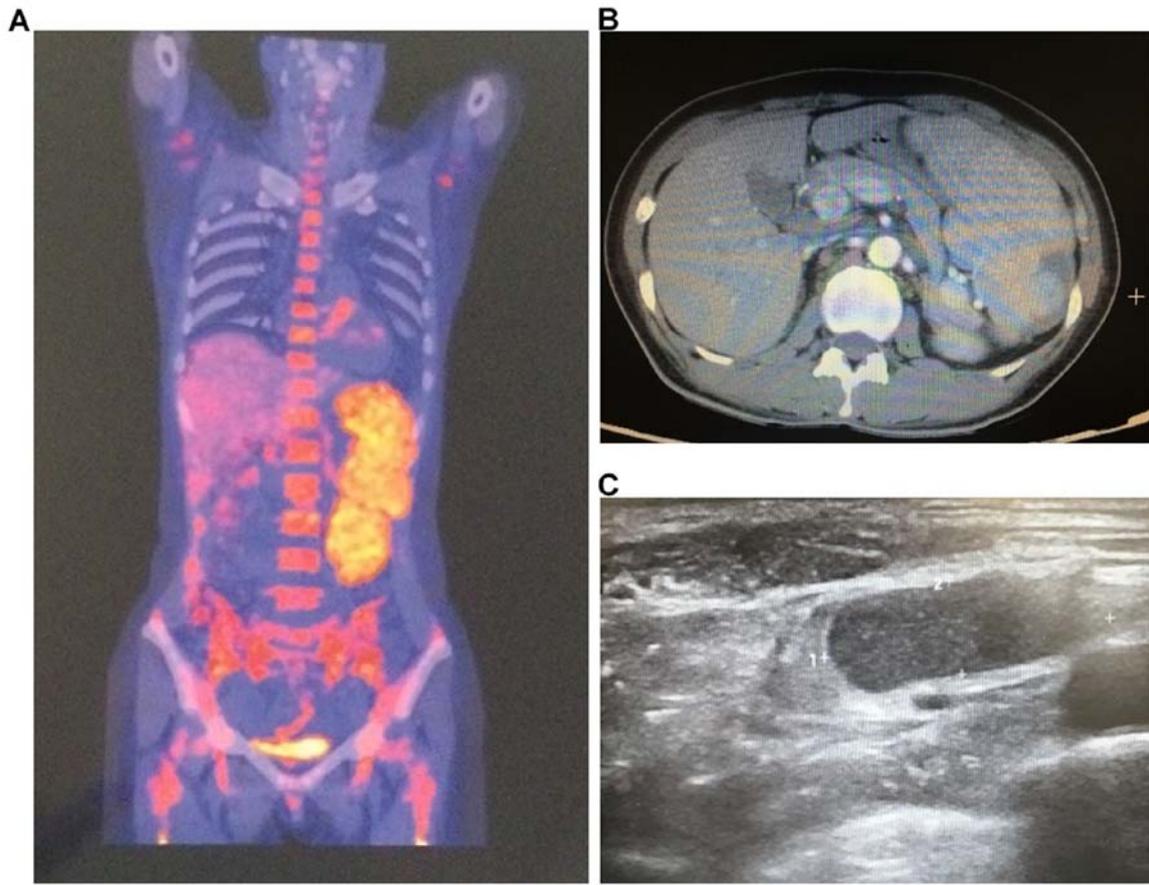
(A) Positron emission tomography-computed tomography (CT). (B) Abdominal CT shows marked enlargement of the spleen. (C) Ultrasound shows enlarged lymph nodes in the clavicle.
